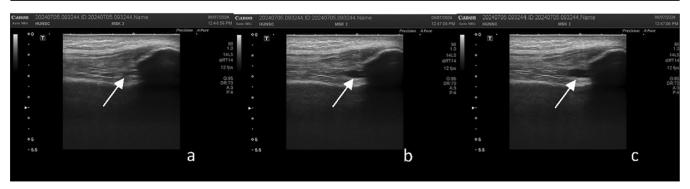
Ultrasound image of infiltration of the knee by lateral, out-of-plane approach in superexternal recess and filling of the recess with hyaluronic acid a, b and c.
